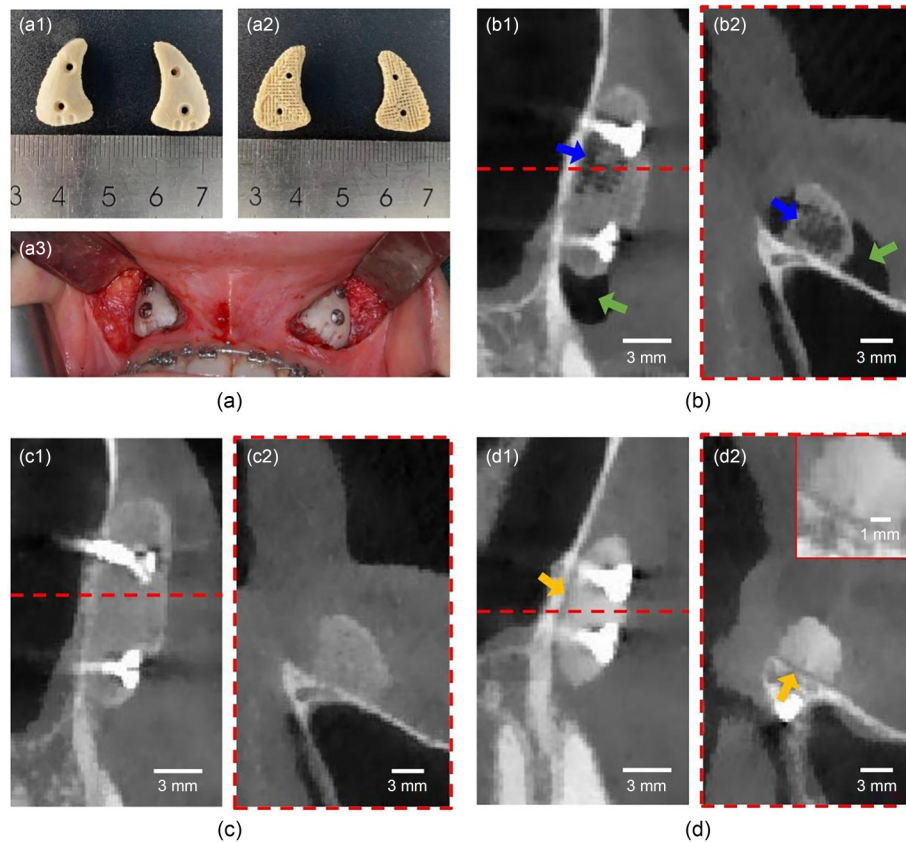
Representative intraoperative photos and postoperative CT images. (a) Front (a1) and back (a2) of 3D-printed porous PEEK implants. (a3) PEEK prostheses after implantation. (b) CT images of the 3D-printed porous PEEK implant at 3 days post-intervention: (b1) coronal plane; (b2) sagittal plane. The blue arrow indicates the porous structure and the green arrow points to the incisions. (c) CT images of the 3D-printed porous PEEK implant at 3 months post-intervention: (c1) coronal plane; (c2) sagittal plane. (d) CT images of the 3D-printed solid PEEK implant at 3 months post-intervention: (d1) coronal plane; (d2) sagittal plane. The yellow arrow points to the gap between the bone and the implant. PEEK: polyether ether ketone; CT: computed tomography
